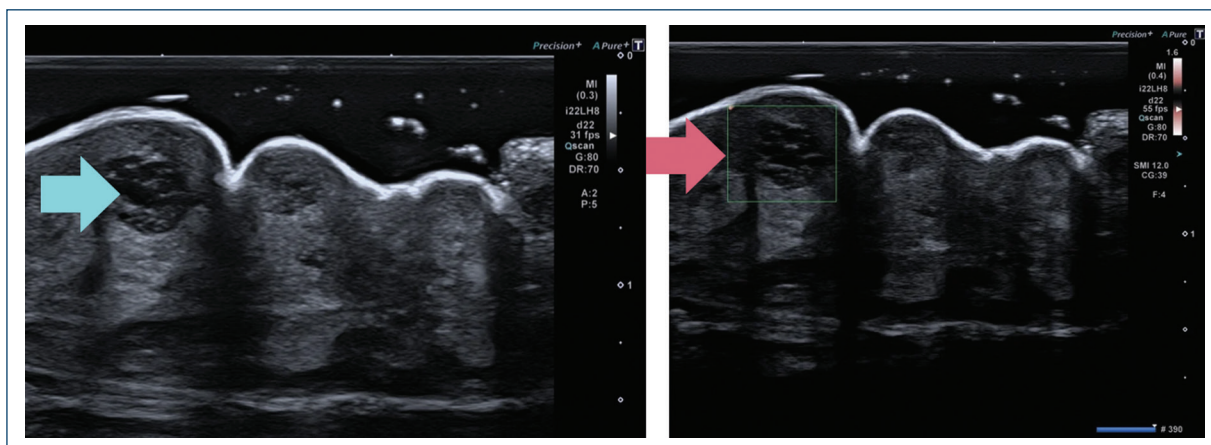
High-frequency ultrasound demonstrating anechoic and hypoechoic dermal structures without detectable flow on superb microvascular imaging, compatible with lymphatic-like spaces.
